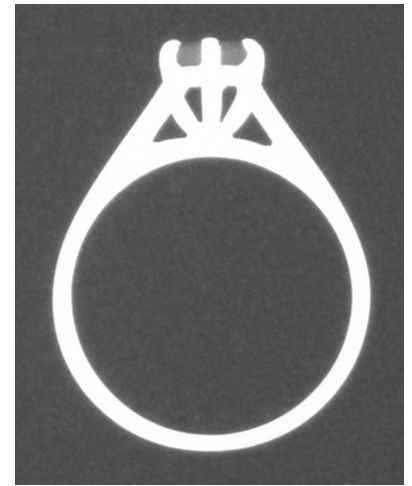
Radiograph of a diamond.
